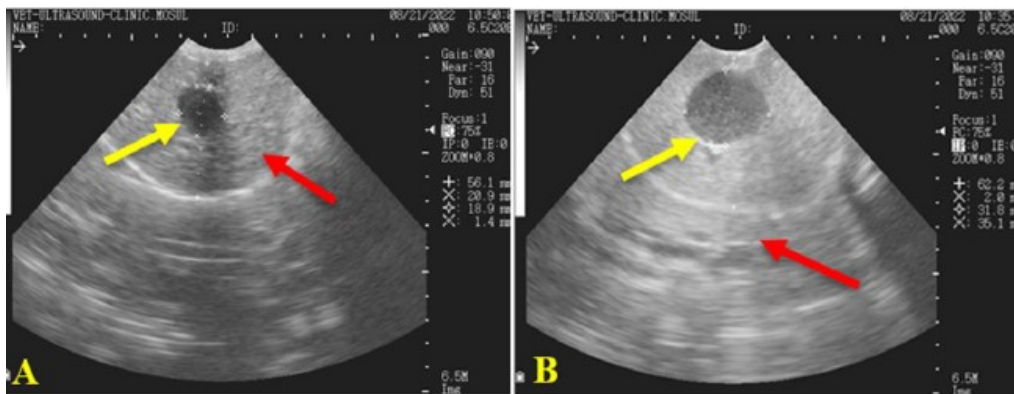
Ultrasonography of liver (A) at 0 day shows normal liver tissue (red-arrow) and normal gall bladder (yellow-arrow), (B) at 21 days shows increase in the size and thickening of the wall of gall bladder (yellow-arrow) and heterogeneous mottled appearance of liver tissue (red-arrows).
